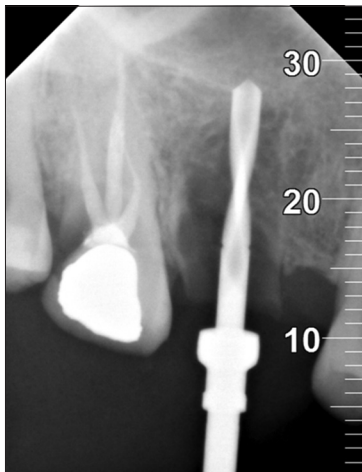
Periapical radiograph of pilot drill preparing for the implant bed in the middle of the mesiodistal dimension of the tooth after the socket shield was prepared
